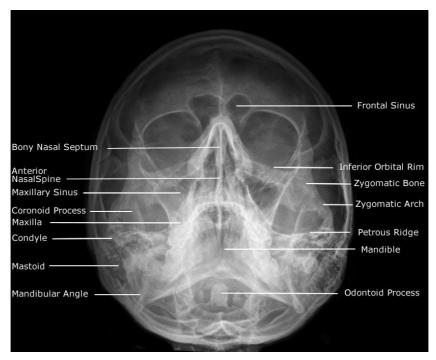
Plain radiograph of head region in Waters view or orbitomeatal view. This is taken for the para nasal air sinuses. (FAS: Anterior cranial fossa; EAS: Sella turcica; MAS: Middle cranial fossa).
